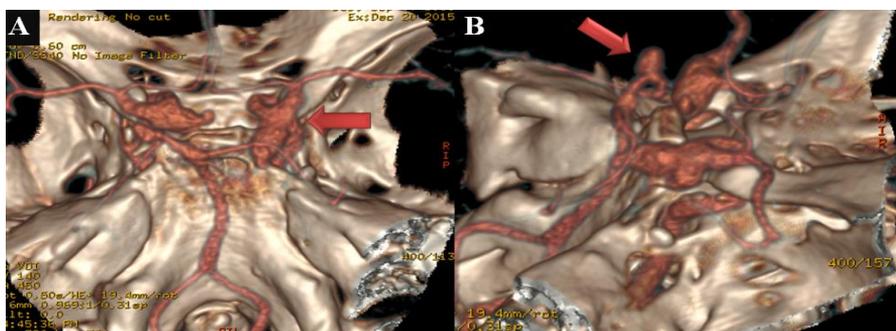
A, B. CTA of the head with 3-dimensional reconstruction of the intracranial vessels showing dysplasia with right PCoA aneurysm (3. A, red arrow) and P1-P2 junction aneurysm (left PCA) (3. B, red arrow).
